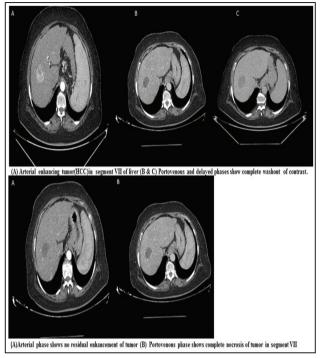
The pre-TACE CT scan of the patient's abdomen with contrast (Triphasic protocol), followed by a post-TACE CT with contrast, revealing a remarkable complete response of the HCC.
